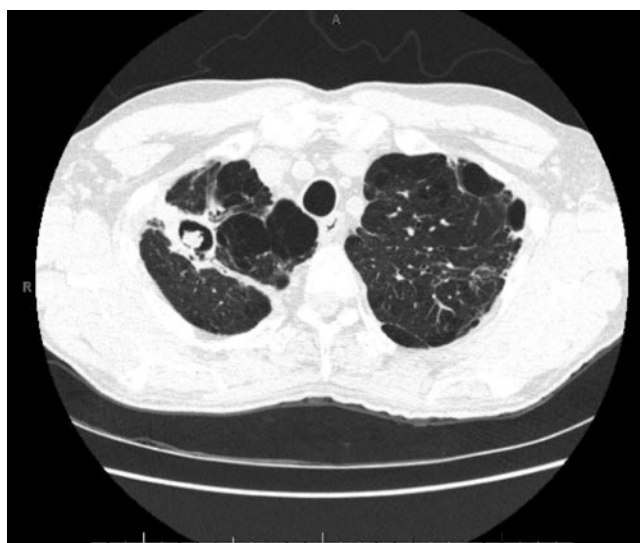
CT scan—Aspergillosis
